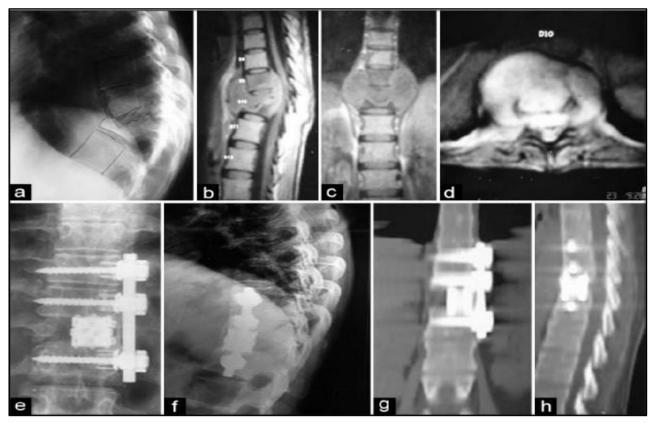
A. Preoperative Lateral Xray A] of 35 Yrs Male with TB Spine D9/D10 Level with Kyphosis Sagittal [B] Coronal [C] Axial [D]
